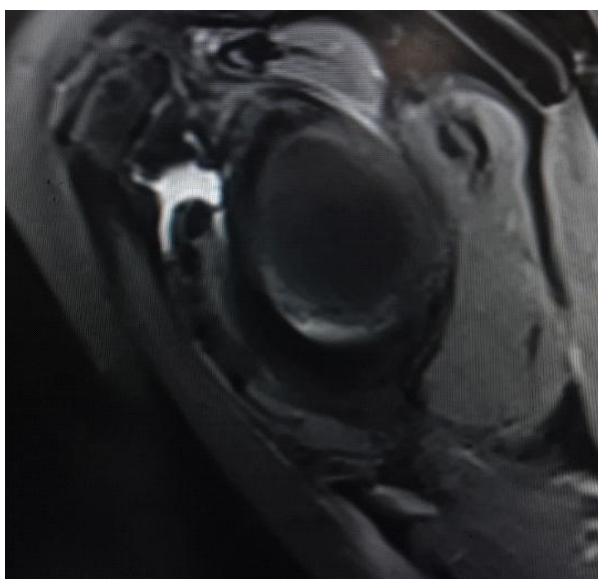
Sagittal oblique MRI Shoulder revealing fluid collection along subscapularis tendon consistent with Subscapularis bursitis.
